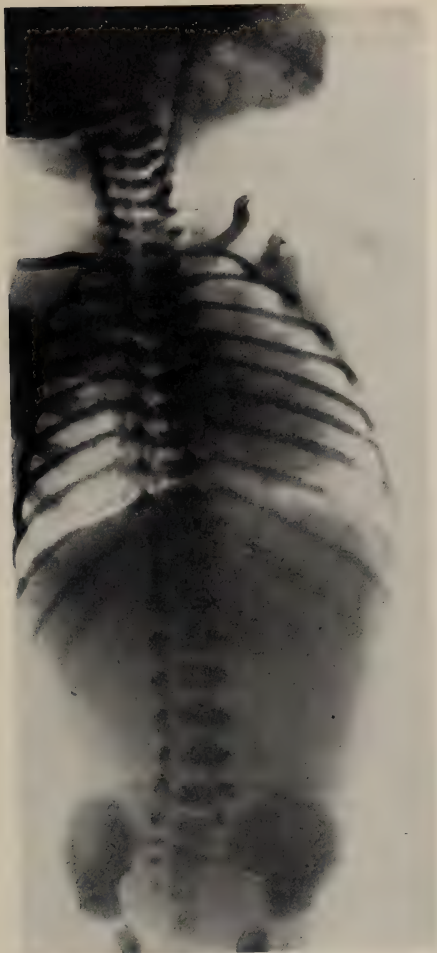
Roentgenogram of the chest and abdomen (without the use of contrast medium) on admission showing an absence of air in the gastrointestinal tract, a catheter in the esophagus obstructed at the level of the seventh cervical vertebra, and a consolidation of the upper third of the right lung.
